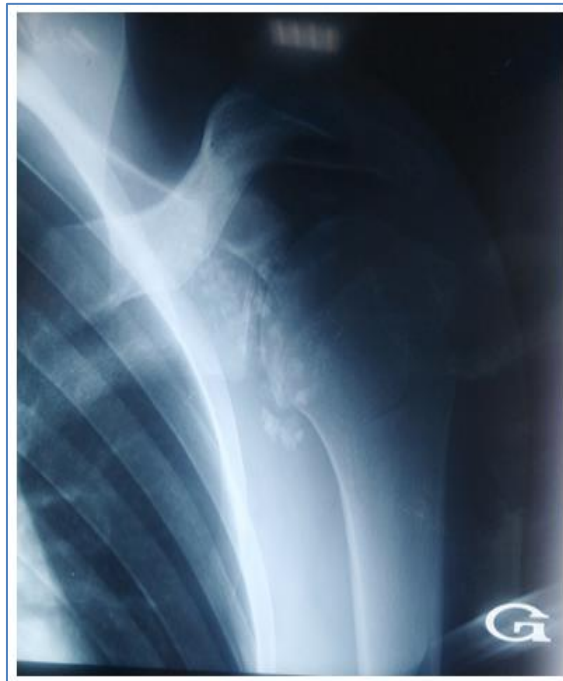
Plain radiography of the shoulder demonstrating multiple calcified intra-articular loose bodies
